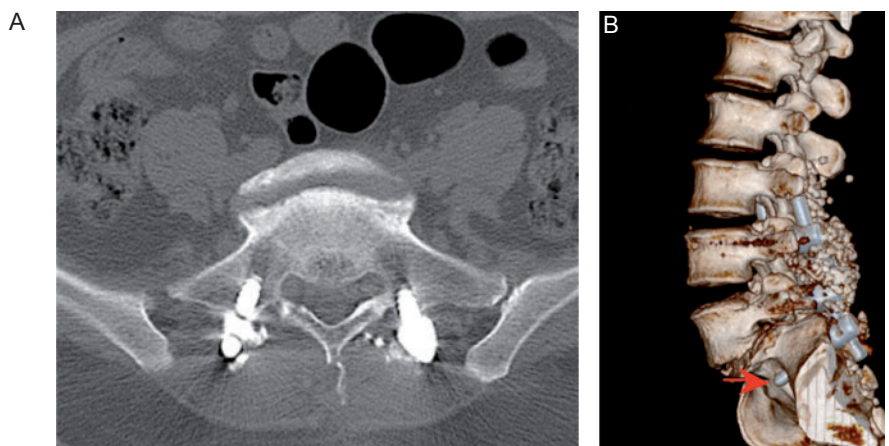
(A) Axial CT slice showing full bone insertion of screws without intra-neural insertion. (B) Clearly visualized vertebral anterior wall perforation (arrows) in the same patient.
